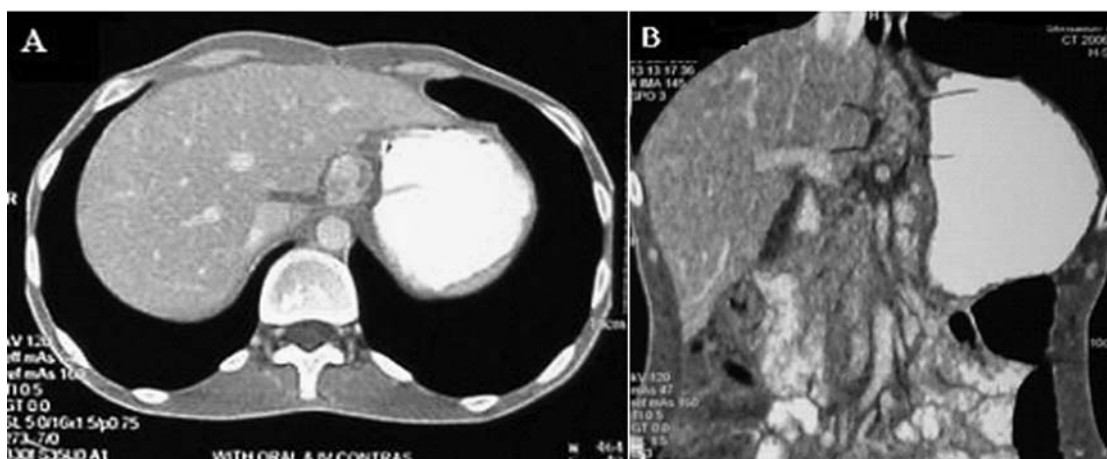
Enhanced computed tomographic (A) axial scan and (B) coronal scan reveal a mass parallel to esophagus.
